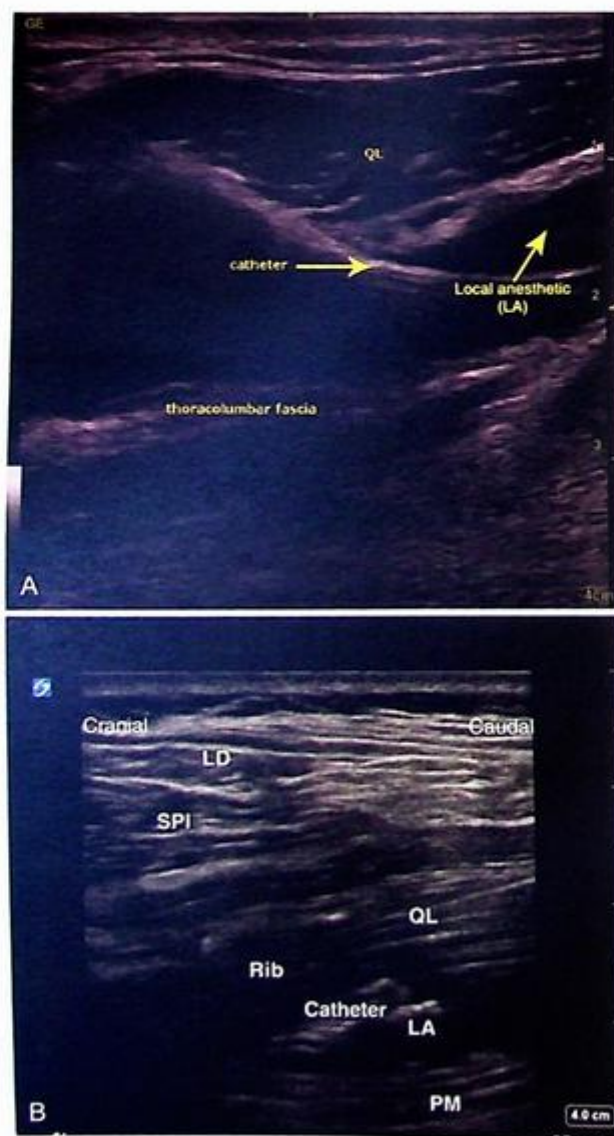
Ultrasound picture of the local anesthetics (LA) spread and catheter placement through the subcostal approach. (A) Between the quadratus lumborum (QL) and thoracolumbar fascia. (B) Between the QL and psoas major (PM). LD, Latissimus dorsi; SPI, serratus posterior inferior.
